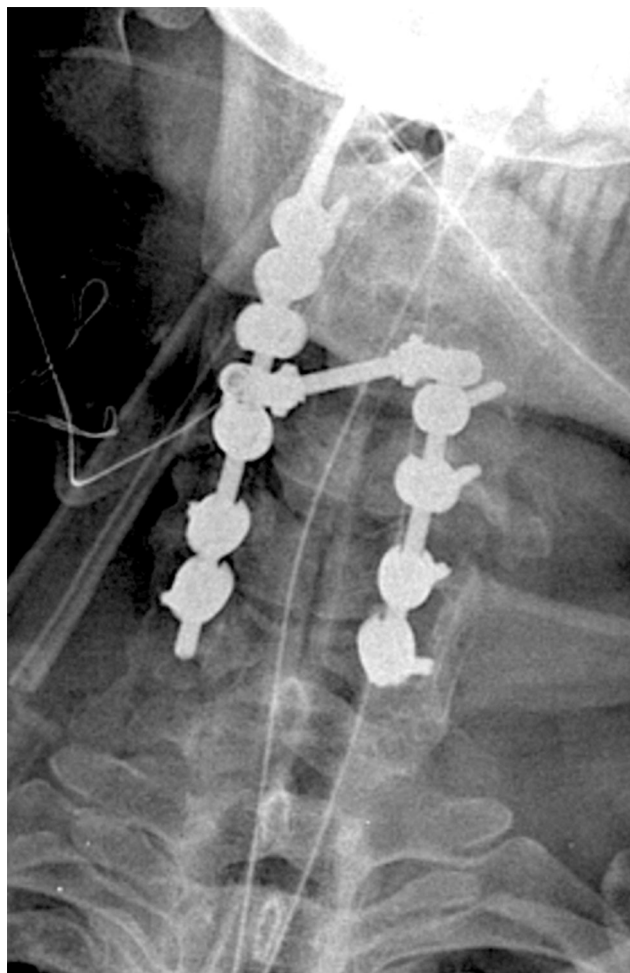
Postoperative X-ray of the cervical spine showing a transverse connector put across both the rods.
